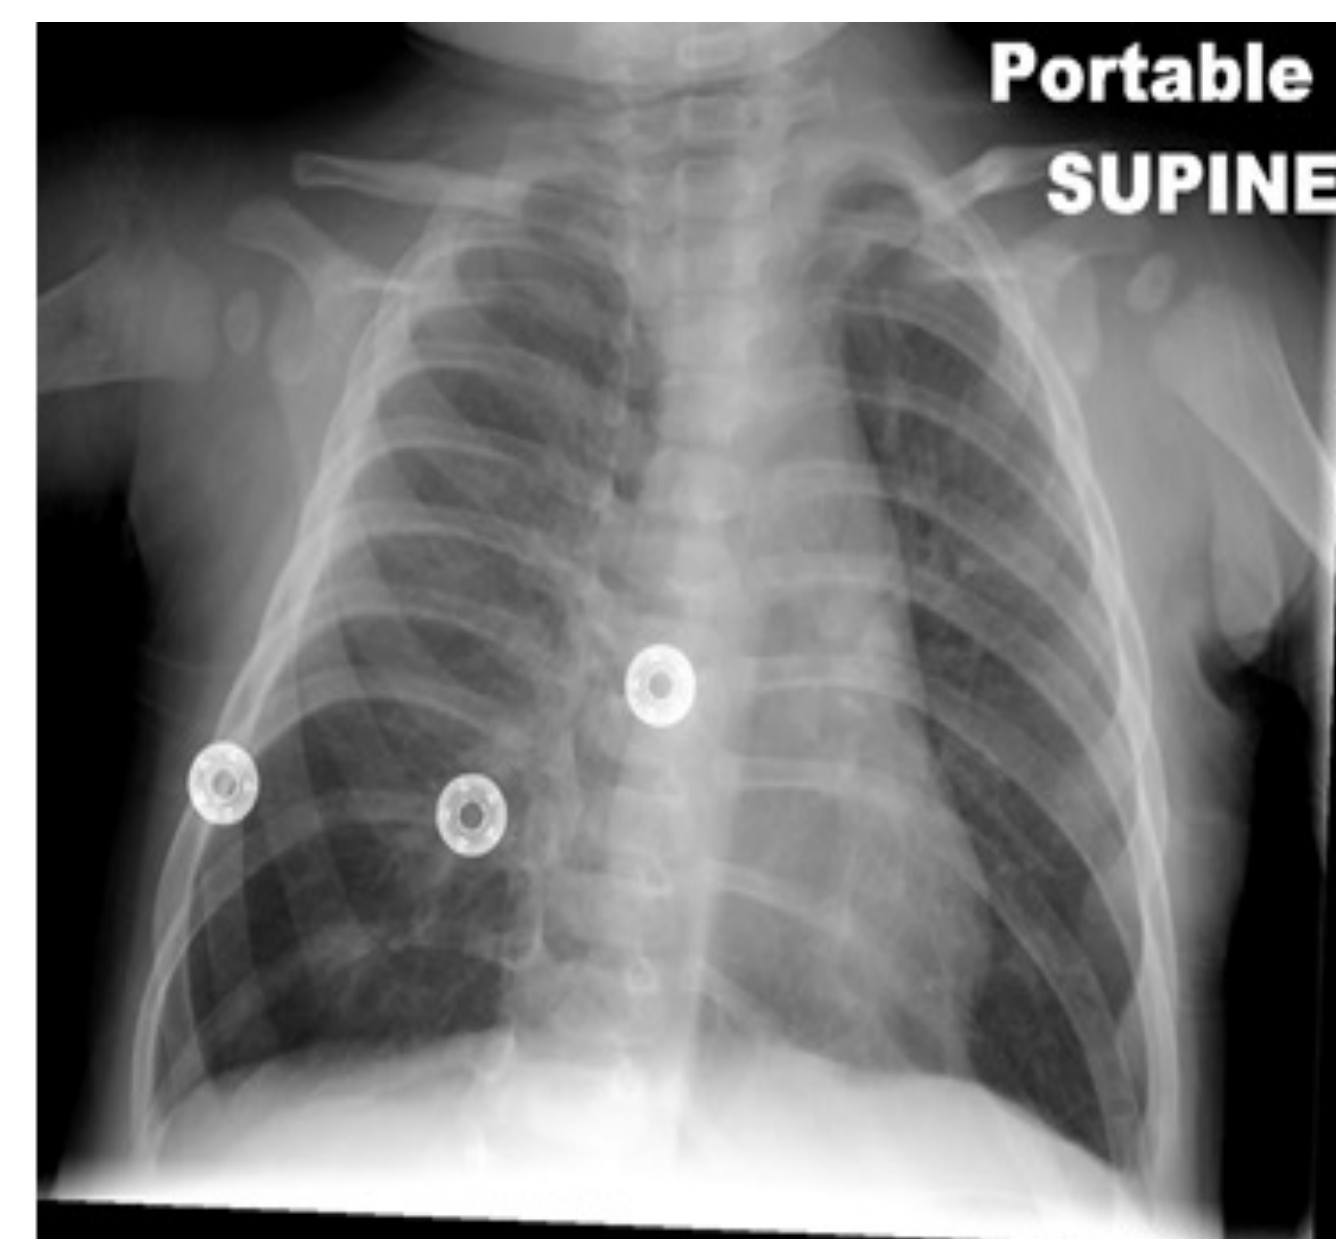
Chest radiograph showing hyperinflated lungs, mild interstitial and bronchial wall thickening throughout the lungs, central peribronchial opacities bilaterally, and atelectasis.
